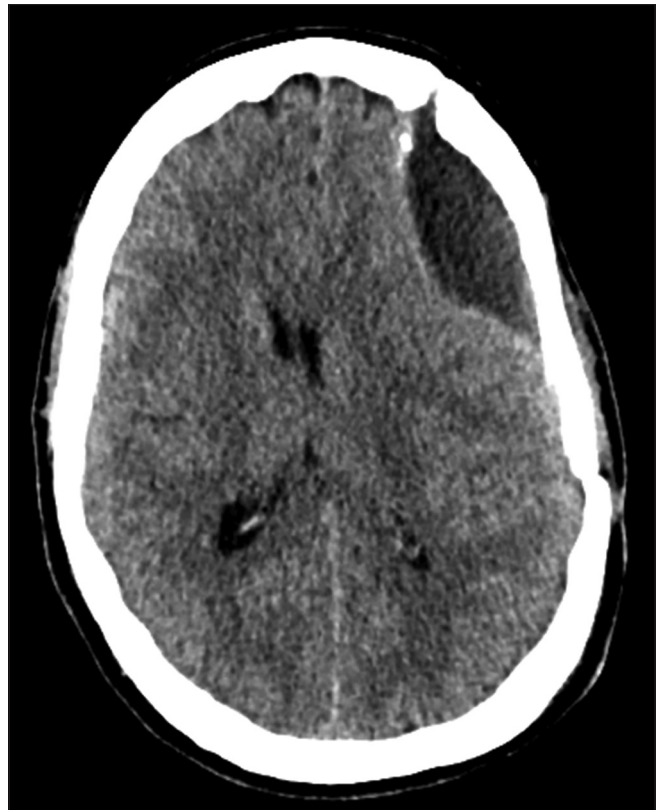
Computed tomography scan of the brain demonstrating recurrence of extradural collection causing subfalcine herniation
